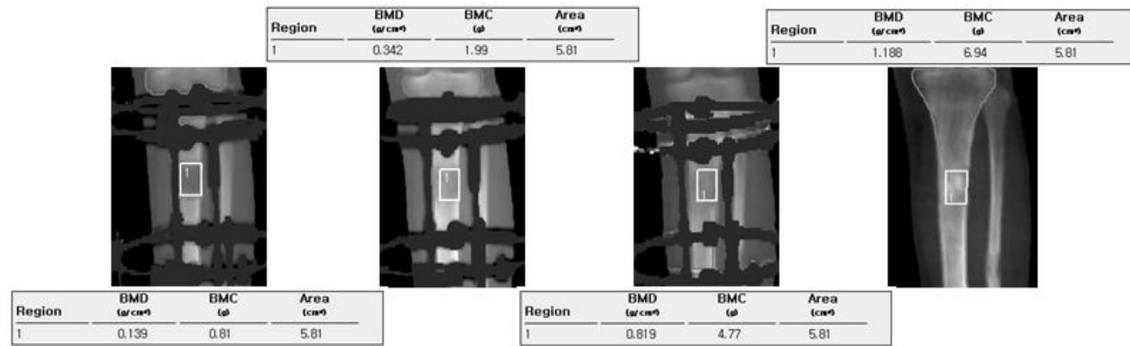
Example of dual energy X-ray absorptiometry bone mineral density (BMD) evaluation over time in the same area. BMC, bone mineral content.
